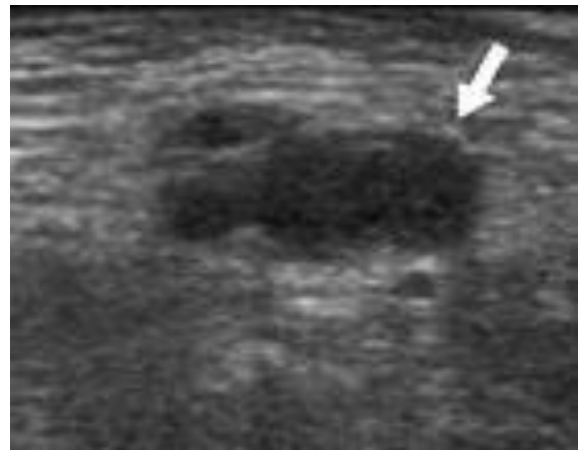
Venous Doppler showing lack of compressibility of the left femoral vein (white arrow) suggestive of the presence of deep vein thrombosis.
